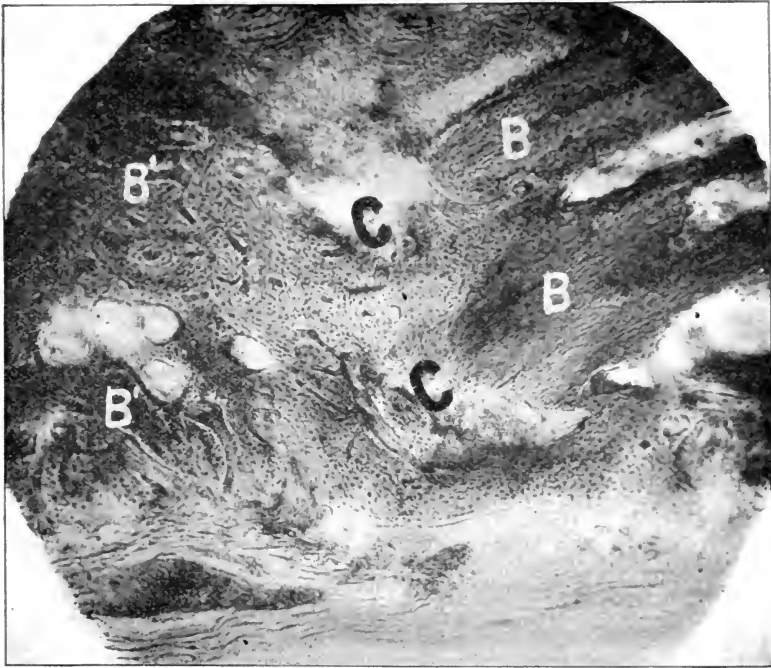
Microphotograph of a section through the site of union, of the healed fracture in the transplanted phalanx, removed from the muscles of the back at the end of 73 days. Notice the old bone at *B*, with the intervening new bone, *C*, which is the result of the inherent proliferating power of the cells of the transplant. This section is through the narrow neck of bone shown in the roentgenogram, Fig. 1.
